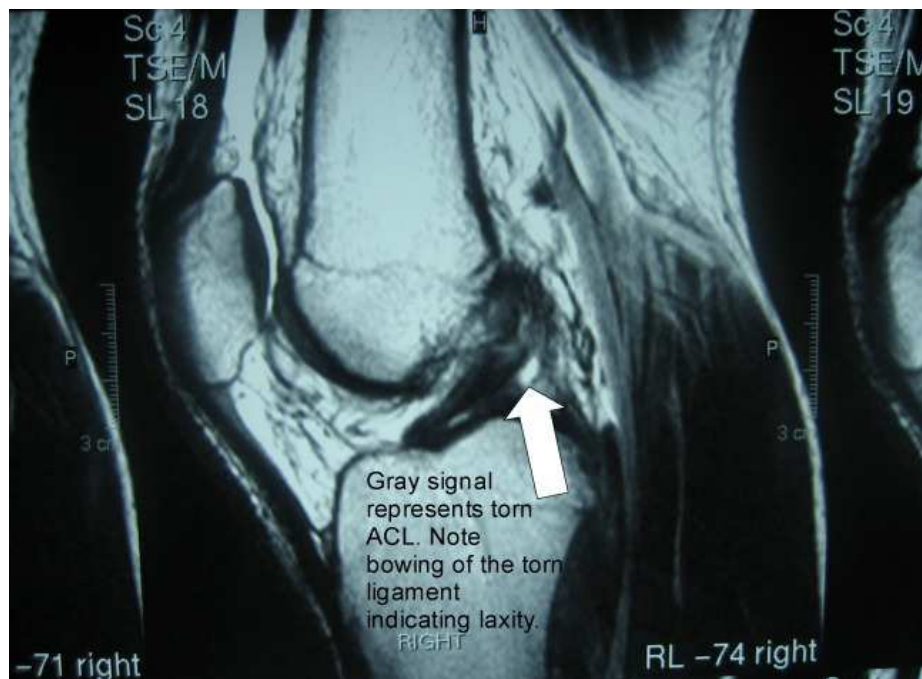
MRI showing injured ACL
